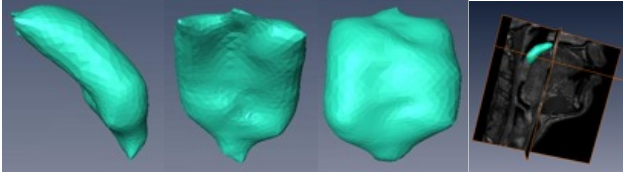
Soft palate surface in 3D. (a) Sagittal view, (b) Coronal view, (c) axial view. (d) Soft palate segmentation localized in the MR image space.
